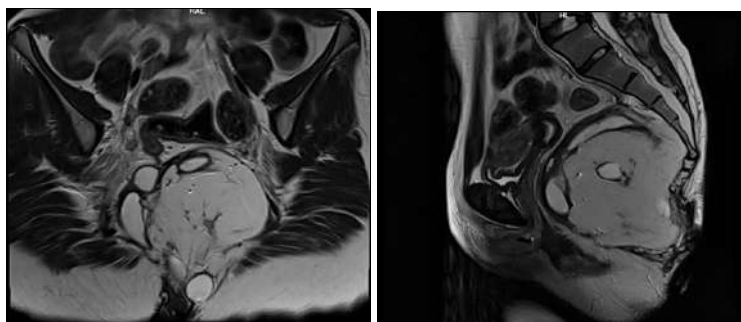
MRI showing large, round retro-rectal mass with predominantly fatty content
